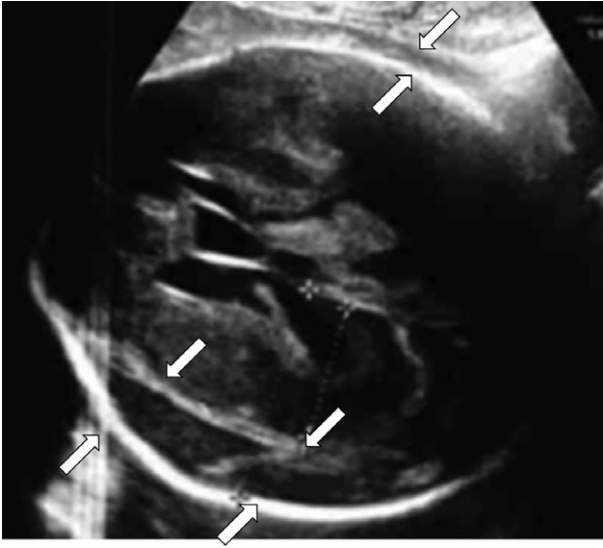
Transverse sonogram showed enlarged biparietal diameter at 26 weeks. Arrows indicate subdural hemorrhage.
